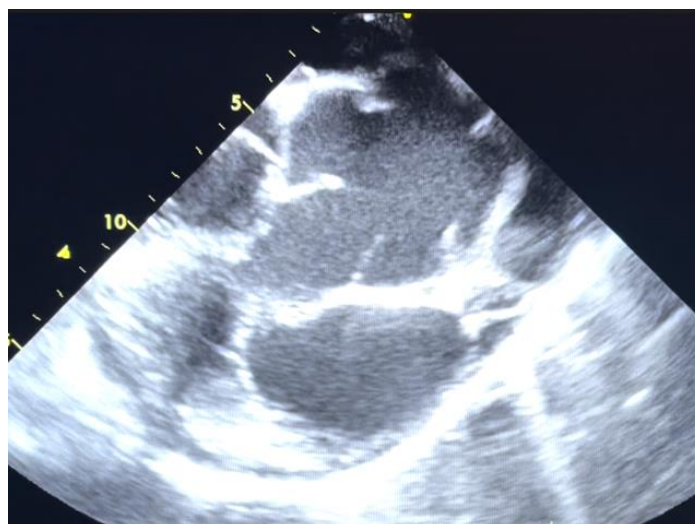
Transthoracic echocardiography showing a dilated aorta
